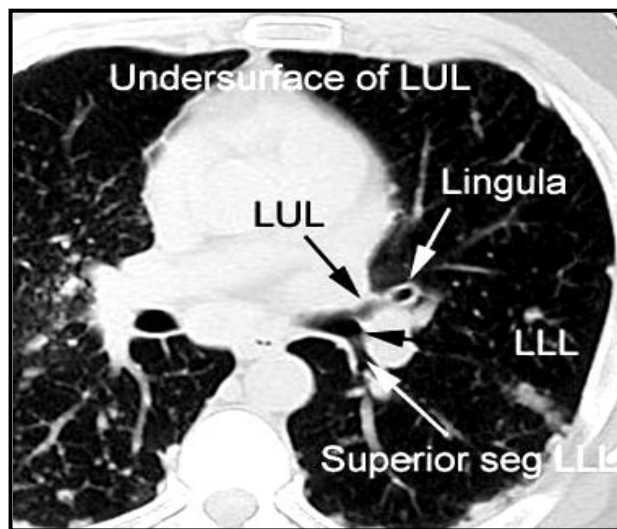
axial CT cuts of the segmental branches of the Lift main bronchus (*Gruden, et al, 2000*).
